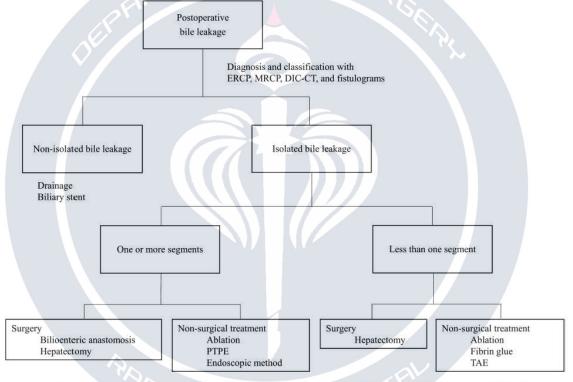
Postoperative bile leakage was diagnosed and classified by endoscopic retrograde cholangiopancreatography (ERCP), magnetic resonance cholangiopancreatography (MRCP), drip-infusion cholangiography with computed tomography (DIC-CT), and fistulograms. Therapeutic strategy of isolated bile leakage was classified by the quantity of bile leakage and as either surgical or non-surgical treatment. When the isolated bile leakage was from less than one liver segment, the first choice of treatment method was non-surgical treatment such as ethanol ablation. When the isolated bile leakage was from more than one segment, the first choice of treatment method was surgical treatment. PTPE, percutaneous transhepatic portal vein embolization; TAE, transcatheter arterial embolization
